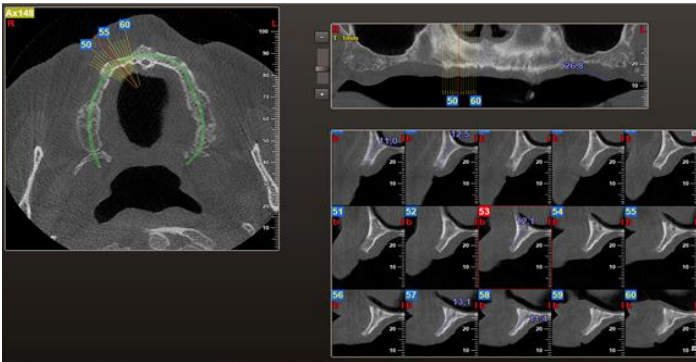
CBCT: sections of the first quadrant.
